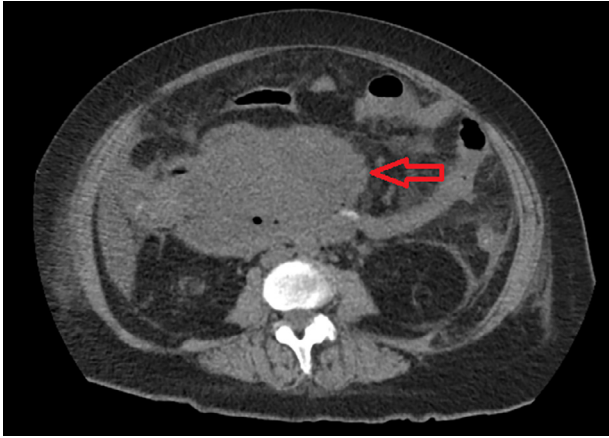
CT scan, axial section, showed a large heterogeneous necrotic cystic/solid mass in the right small bowel mesentery measuring 9.5 × 15 cm (red arrow).
